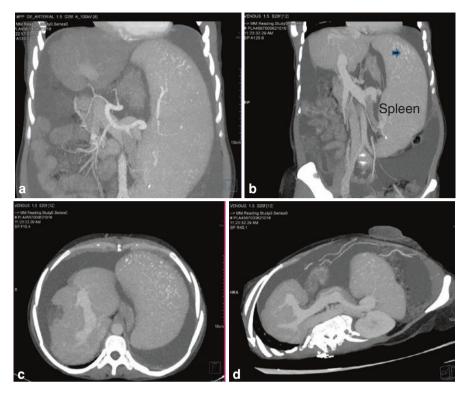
Coronal arterial phase CT image showing splenomegaly with enlarged splenic artery (a); Coronal venous phase CT image showing dilated splenoportal axis, splenomegaly, Gamna-Gandy bodies (solid arrow) and ascites (b) Axial and oblique axial CT images showing dilated splenoportal axis with abrupt change in calibre of the intrahepatic portal vein (c & d). Courtesy: Dr Madhusudhan KS, Department of Radiodiagnosis, AIIMS, New Delhi, India
